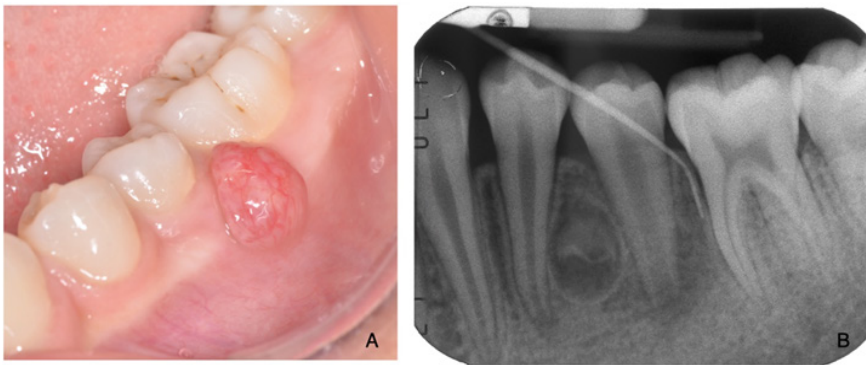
Preoperative intraoral photograph, showing the initial presentation of the sinus tract corresponding to 35 (A). Preoperative periapical radiograph showcasing both the supernumerary premolar and the extent of the periapical lesion before any intervention. A gutta-percha cone indicates the sinus tract (B).
